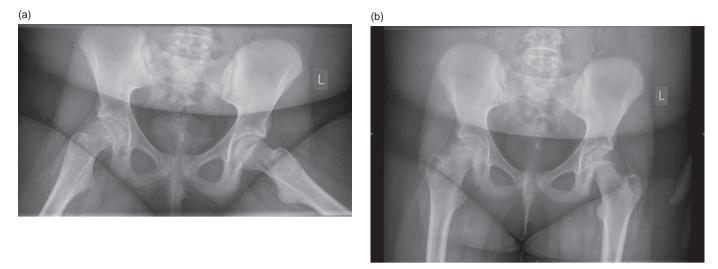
(a,b) Example AP and frog-leg lateral x-rays of a child with a right chronic mild SUFE demonstrating the features described above
